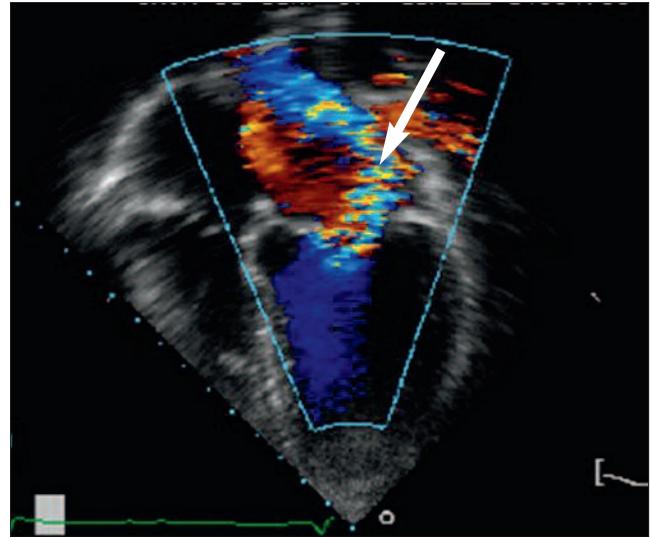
Echocardiogram demonstrating mitral regurgitation due to rheumatic valvulitis (arrow).
